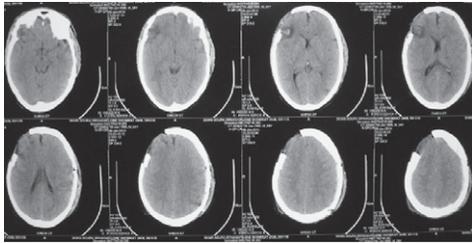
CT head after second surgery and both hematomas been evacuated completely with both craniotomies
